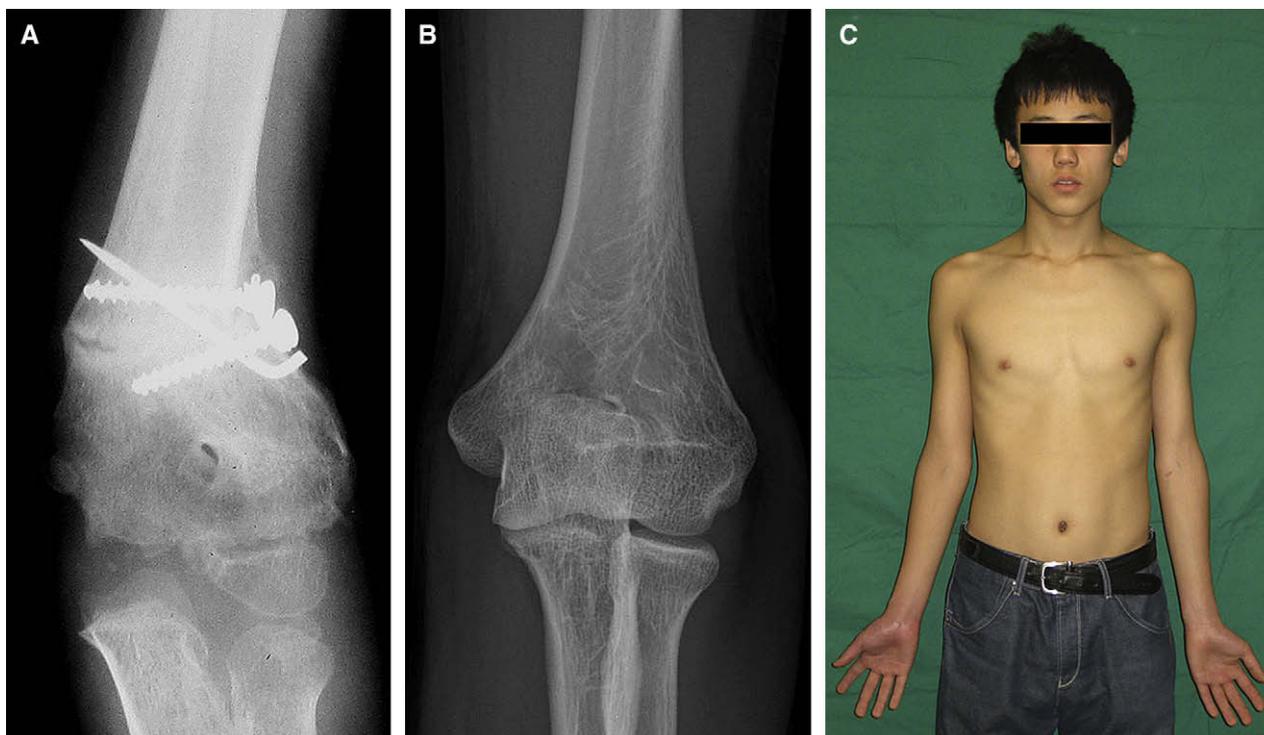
A, Anteroposterior radiograph shows lateral displacement of a distal fragment at 5 weeks after lateral closed-wedge osteotomy. B, Anteroposterior radiograph obtained at 8.1 years after surgery shows remodeling of the lateral condylar prominence. C, Surgery produced a satisfactory cosmetic result.
